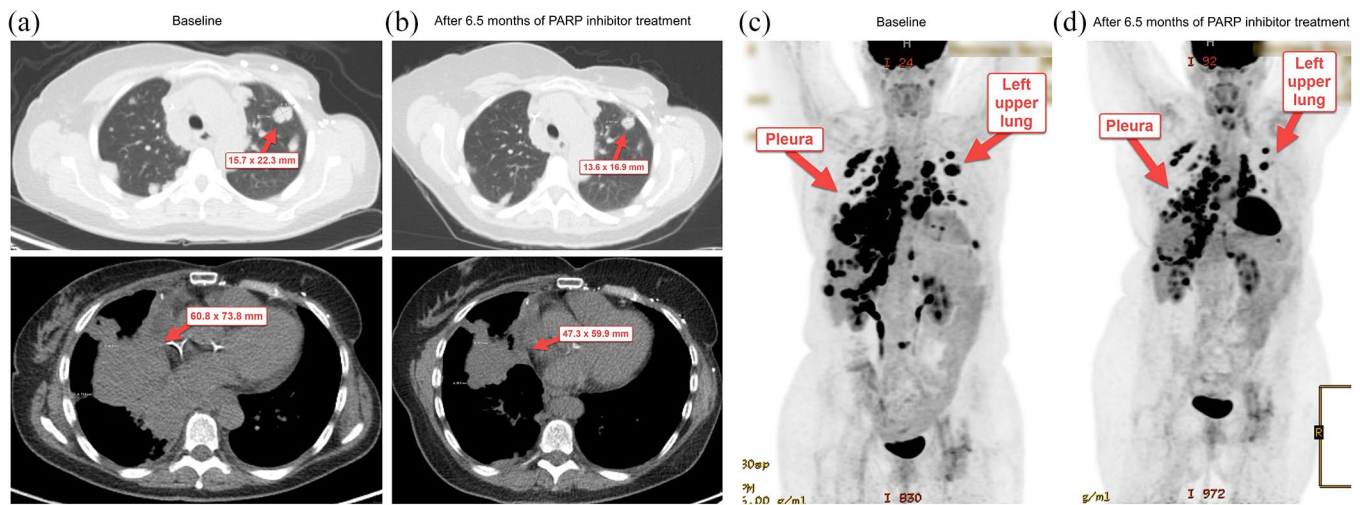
Changes in tumor measurement from baseline in patient 003, who underwent treatment with PARP inhibitor on the basis of ctDNA analysis showing *BRCA1 Q356 mutation. (a) Representative computed tomography (CT) images from the patient at baseline. (b) Representative CT images from the patient after 6.5 months of treatment with PARP inhibitor. (c) Representative positron emission tomography (PET) overview image from the patient at baseline. (d) Representative PET overview image from the patient after 6.5 months of treatment with PARP inhibitor. Red arrows indicate target lesions.
